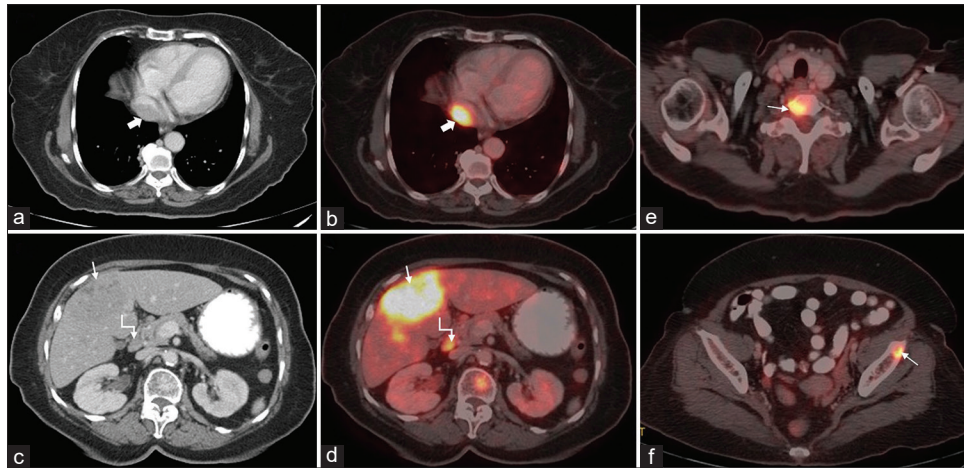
(a-d) Axial contrast-enhanced computed tomography and corresponding positron emission tomography/computed tomography (PET/CT) fusion images of chest and abdomen show mildly enhancing hypoaattenuating hypermetabolic lesion in the inferior cavoatrial junction (thick arrows), metastases in liver (arrows), and enlarged precaval lymph node (elbow arrows). (e and f) Axial PET/CT fusion images of the neck and pelvis show bone metastases in vertebral body and left iliac bone (arrows).
